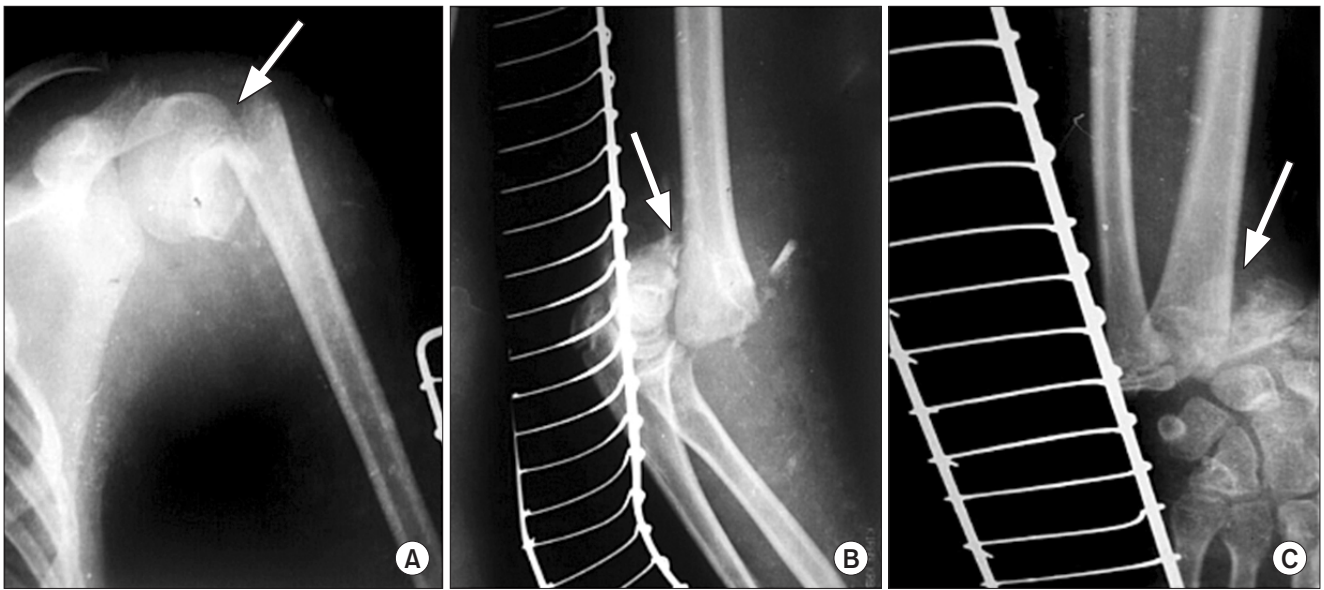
Floating upper limb. X-rays showing injury of the ipsilateral humeral (A), supracondylar (B), and distal radial limb (C; 7 hours post injury). Each arrow indicates the point of injury.
